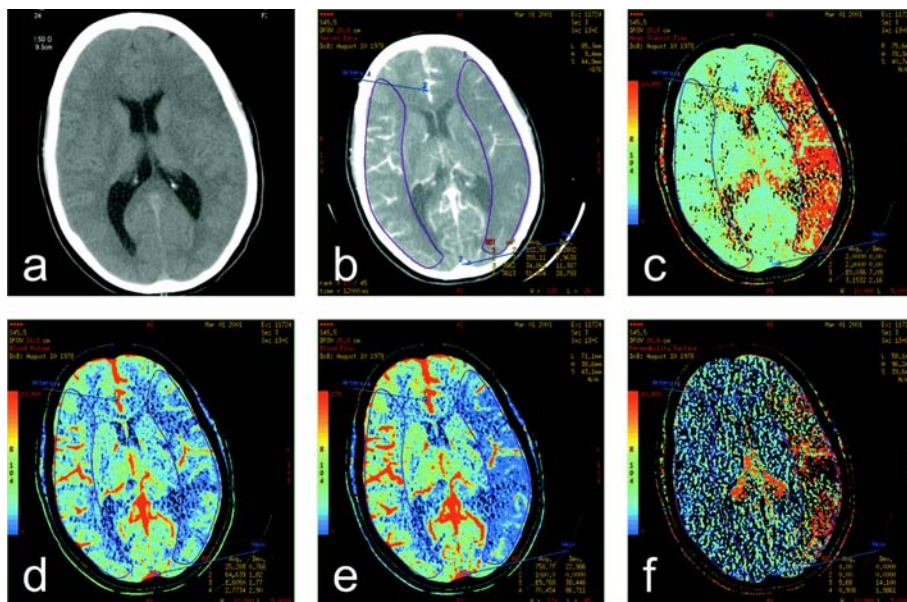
CT and CTP in a 21-year old female after cardiac embolism and complete hemiparesis of the right side. CTP was performed 2:50 hours after attack. (a) CT after 2:50 hours shows no early infarct signs. (b) during maximum of contrast bolus passage less mca-branches on the left side are visible, reduced perfused CBV in left mca territory. (c) MTT-map demonstrates prolongation MTT in the territory of left mca up to 10 sec, right side 3 sec. (d) CBV-map, affected side 1,6 ml/100g, contralateral 2,7 ml/100g. (e) flow reduction in the left mca territory to 20 ml/100g/min right side 70 ml/100g/min. (f) Permeability-map showing severe extravasation 3 hours after mca-occlusion of 5,6 ml/100g/min (opposite side 0,9 ml/100g/min indicating rupture of the blood-brain-barrier.
